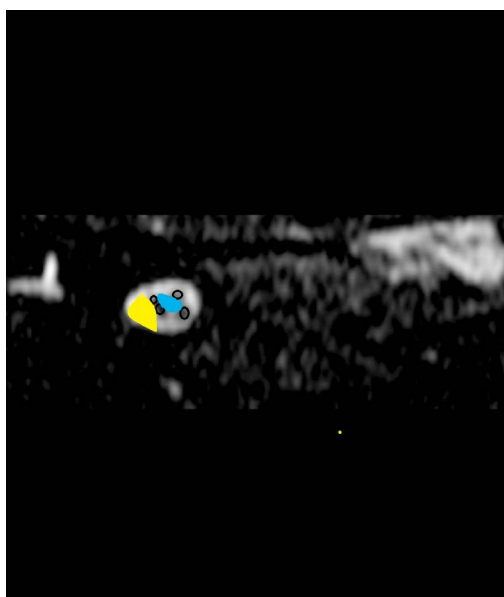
MRI Figure of IAC in T2: in blue Arachnoid Cyst in central position between the nerves, in yellow lateral to the structures.
